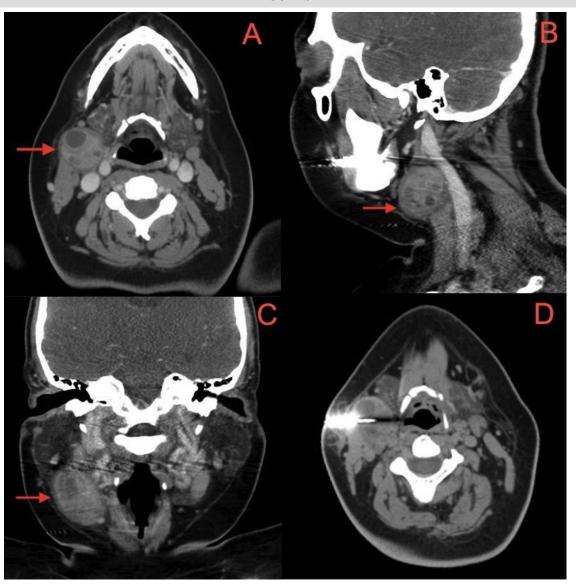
23 year old female presented with a painless palpable right neck mass, which was subsequently diagnosed as IgG4-related disease. FINDINGS: Axial (A), sagittal (B), and coronal (C) contrast enhanced CT of the neck in the venous phase demonstrates a mixed cystic and solid enhancing mass measuring 2.9 cm AP x 3.1 cm transverse x 4.0 cm craniocaudal within the right lateral neck, level IIa (arrows) anterolateral to the common carotid artery and jugular vein with the mass bordering the anterior margin of the sternocleidomastoid muscle. Axial noncontrast CT (D) demonstrates image-guided placement of an 18-gauge spring-loaded biopsy needle into the right neck cystic and solid mass with the needle tip in the center of the lesion; core tissue samples were obtained. TECHNIQUE: A-C: Axial contrast enhanced CT, General Electric LightSpeed VCT, 37 mAs, 120 kVp, 2.5 mm slice thickness, 100 mL Omnipaque 350. D: Axial noncontrast enhanced CT, General Electric LightSpeed VCT, 100 mAs, 120 kVp, 2.5 mm slice thickness.
